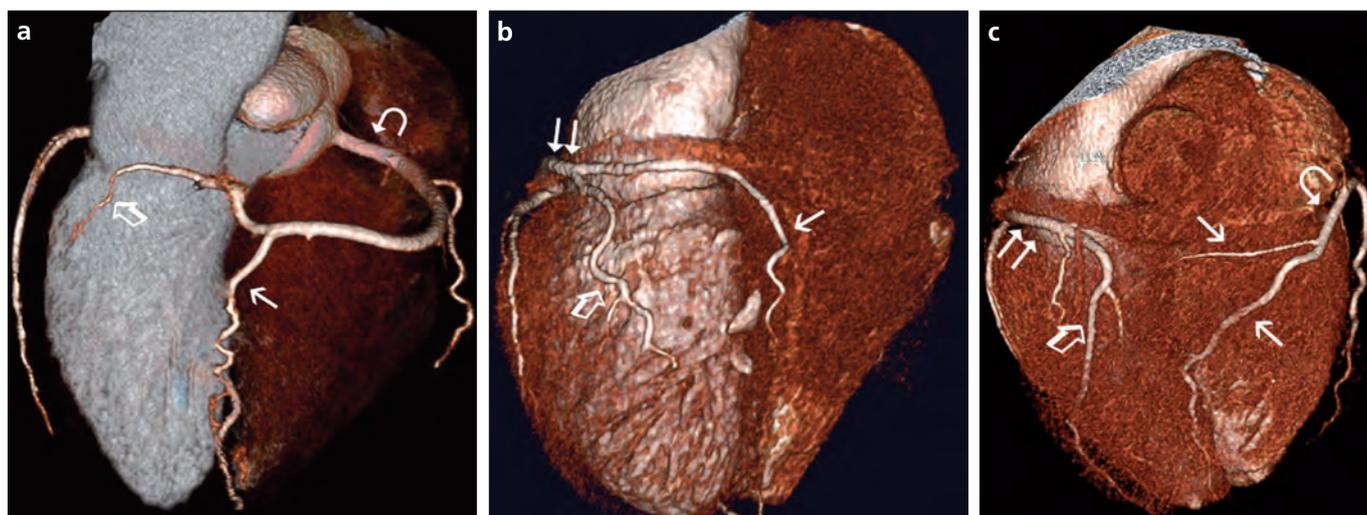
a–c. 3D volume-rendered CT angiography images of different patients. Posterior view of the heart (a) shows a right dominant system with the posterior descending artery (PDA) (arrow) and posterolateral branch (PLB) (open arrow) originating from the right coronary artery (RCA) (curved arrow). Second image (b) shows a left dominant system with the PDA (arrow) and PLB (open arrow) originating from the circumflex artery (Cx) (double arrow). Third image (c) shows a co-dominant system where RCA (curved arrow) supplies the PDA (arrow), and left ventricle posterolateral wall is supplied (posterolateral branch, open arrow) by branches of the Cx (double arrow).
